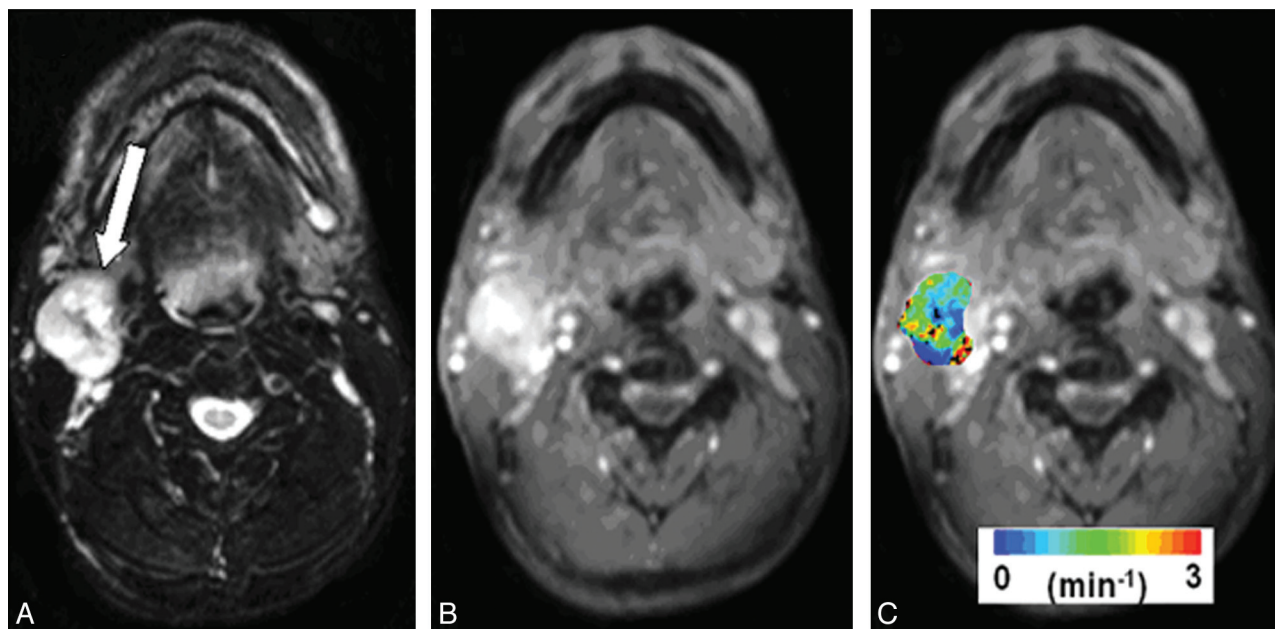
Representative images from a patient with HNSCC before chemoradiation therapy. *A*, Axial T2-weighted image demonstrates a heterogeneous hyperintense metastatic lymph node at level IIa of the right neck (arrow). *B*, This mass exhibits heterogeneous enhancement on a contrast-enhanced T1-weighted image. *C*, DCE-MRI–derived K^{trans} map is shown as a color image overlaid on a postcontrast T1-weighted image.
